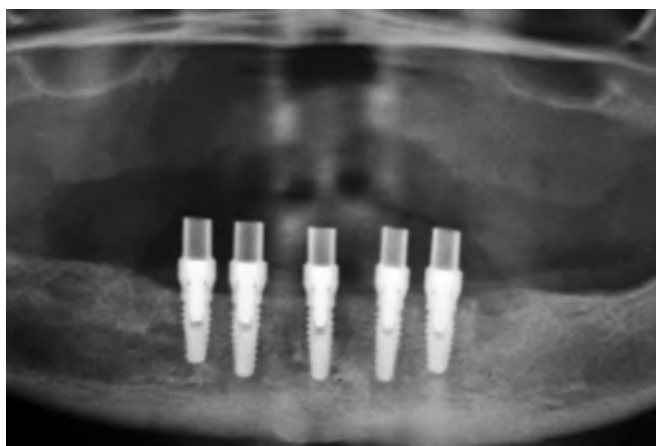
Postoperative panoramic radiograph of the patient in Figure 6.1 immediately post implant placement and abutment connection.
